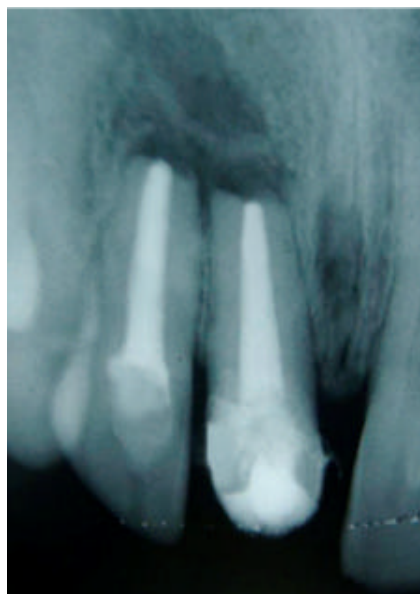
Intra-oral periapical radiograph after 1 year follow up showing periapical bone healing
